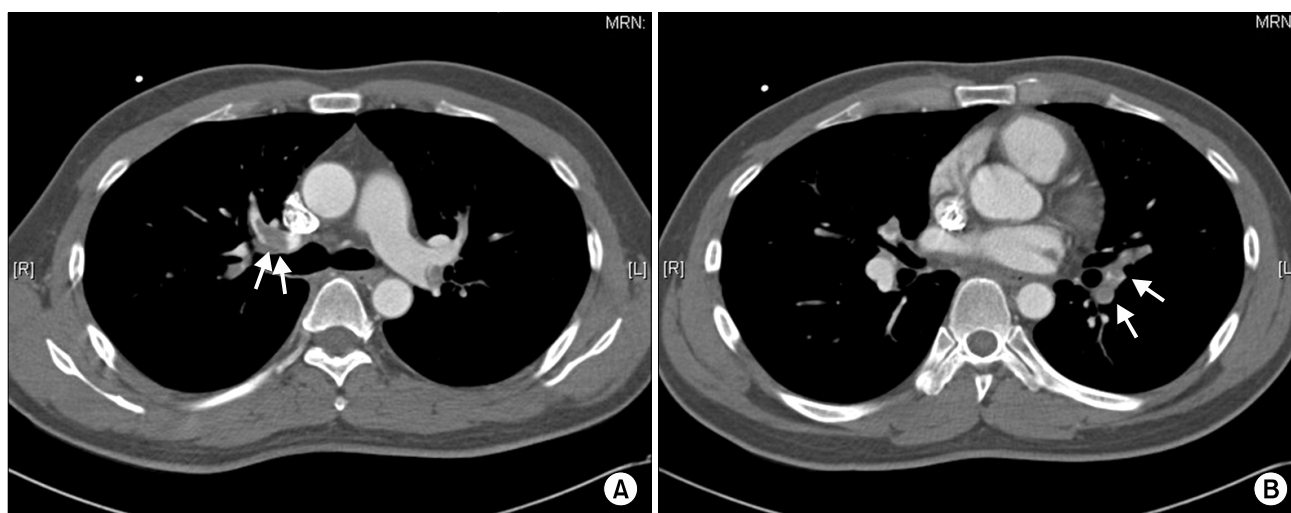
Computed tomography angiogram confirming that the recurrent pulmonary thromboembolism can be seen. (A) Revealed bilateral multifocal defects in the right pulmonary artery (white arrows) and (B) the left pulmonary artery (white arrows).
